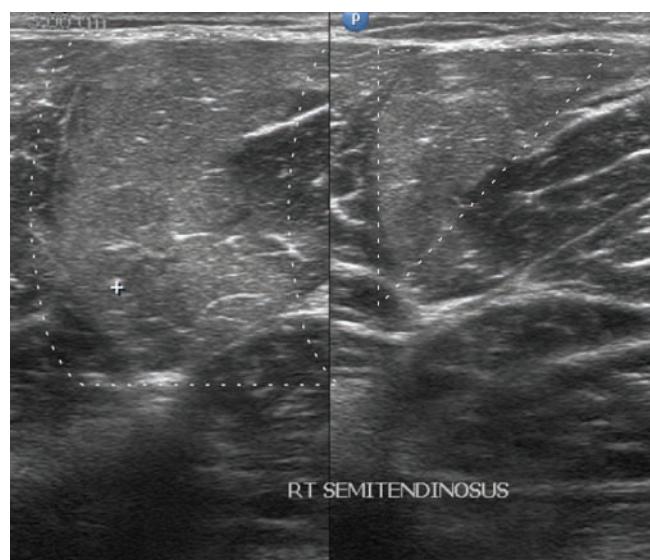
Ultrasound scan of a grade 1 injury according to Peetrons’ classification system. Transverse ultrasound images of the semitendinosus muscle. An area of high reflectivity adjacent to the musculotendinous junction is seen (dotted shapes).
